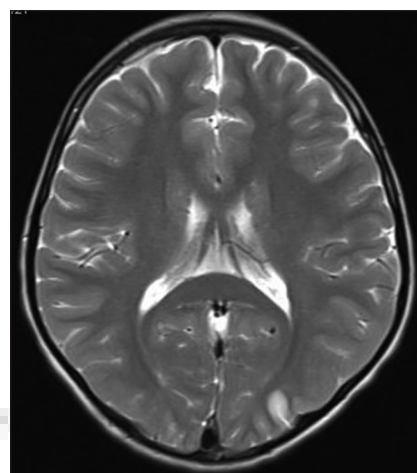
T2-weighted image of the brain shows increased signal within the occipital lobe suggestive of acute infarction
